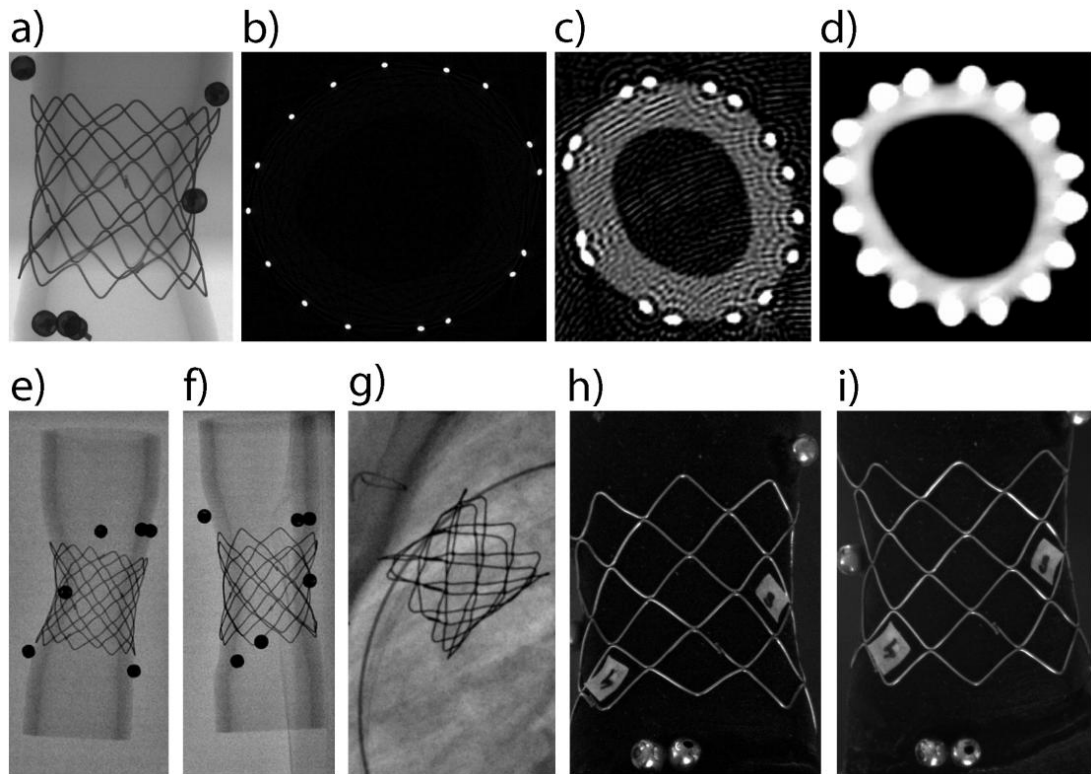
Representative images from each imaging technique (a) Single projection image from uCT, prior to volume reconstruction and (b) cross-sectional image after volume reconstruction. (c) High-dose and (d) Low-dose clinical CT cross-sectional image. (e,f) Biplanar fluoroscopy images in vitro in two orthogonal projections. (g) In vivo fluoroscopy image of a deployed stent in a patient during PPVI. (h,i) Stereo optical images for a single stent position.
